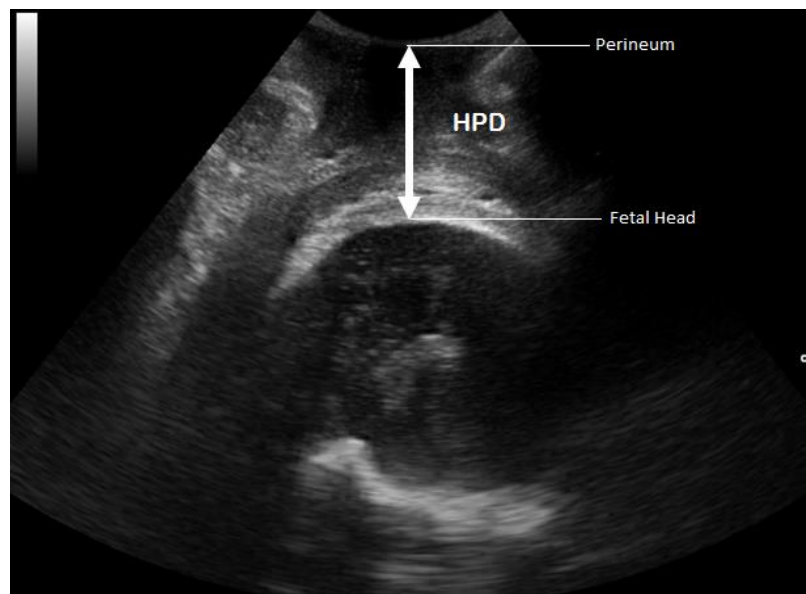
An example of HPD sonographic image (Source: Wiafe et al, 2018)
